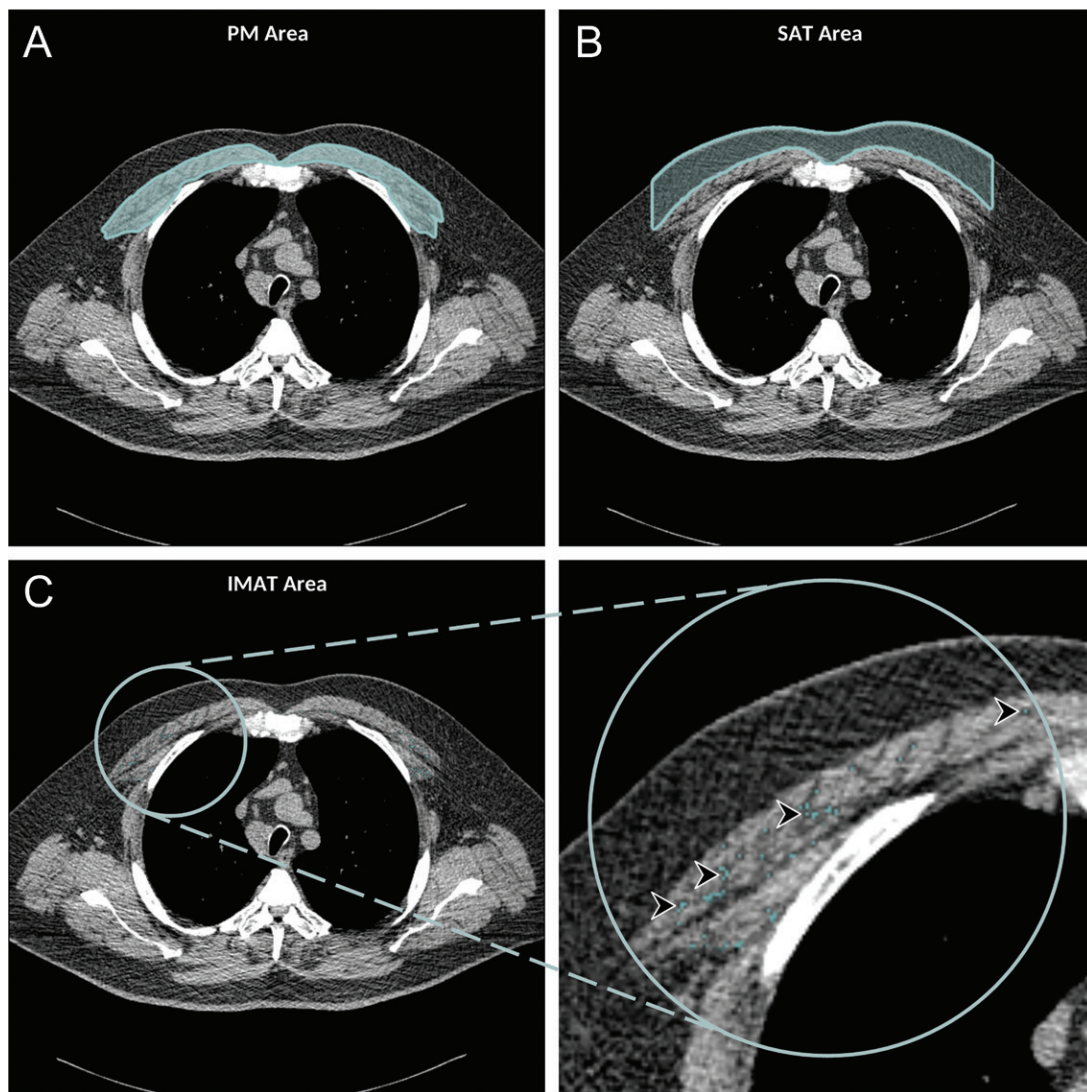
Axial chest CT examination in a 54-year-old participant. A, On the axial noncontrast chest CT image, the pectoralis muscle (PM) area was segmented and measured in the section above the aortic arch. B, The subcutaneous adipose tissue (SAT) area as the area between the PM and the skin surface on the same section was also measured and the attenuation of pixels in the SAT area was used to determine the individualized threshold for the intermuscular adipose tissue (IMAT). C, The IMAT within the PM was segmented as the areas with Hounsfield units below this threshold for the IMAT (arrowheads).
